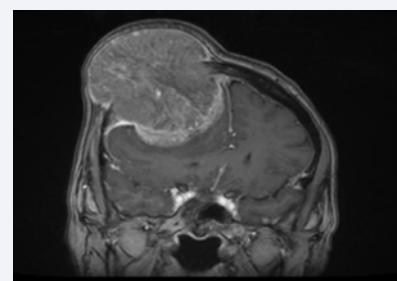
Coronal brain MRI.
